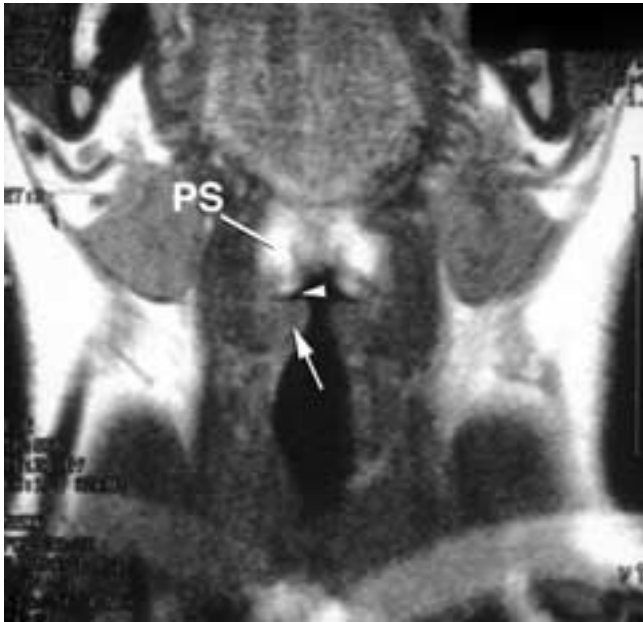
Normal coronal MR image. Coronal image through the larynx shows the triangular TAM (*arrow*) forming the bulk of the true cord. The ventricle (*arrowhead*), preepiglottic space (*PS*).
